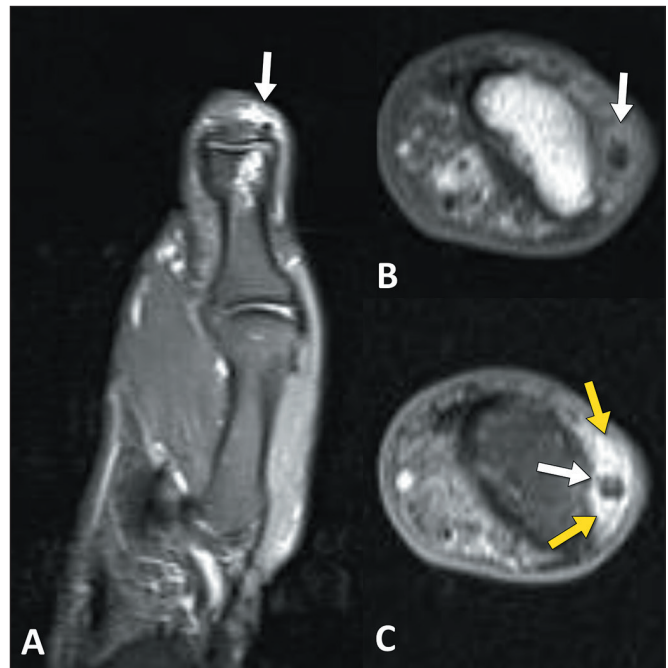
A 63-year-old male patient with pain in the thumb and suspected arthritis. A: Coronal T2-weighted image with fat saturation, showing a small focus of low signal intensity (arrow), with edema in the adjacent adipose planes. Note also the subchondral edema and cystic changes in the head of the proximal phalanx of the thumb. B,C: Unenhanced axial T1-weighted image (B) and contrast-enhanced T1-weighted image with fat saturation (C), showing a small focus of low signal intensity (white arrows) and enhancement in the adipose planes (yellow arrows), without proliferative synovitis that would suggest inflammatory or septic arthritis.
